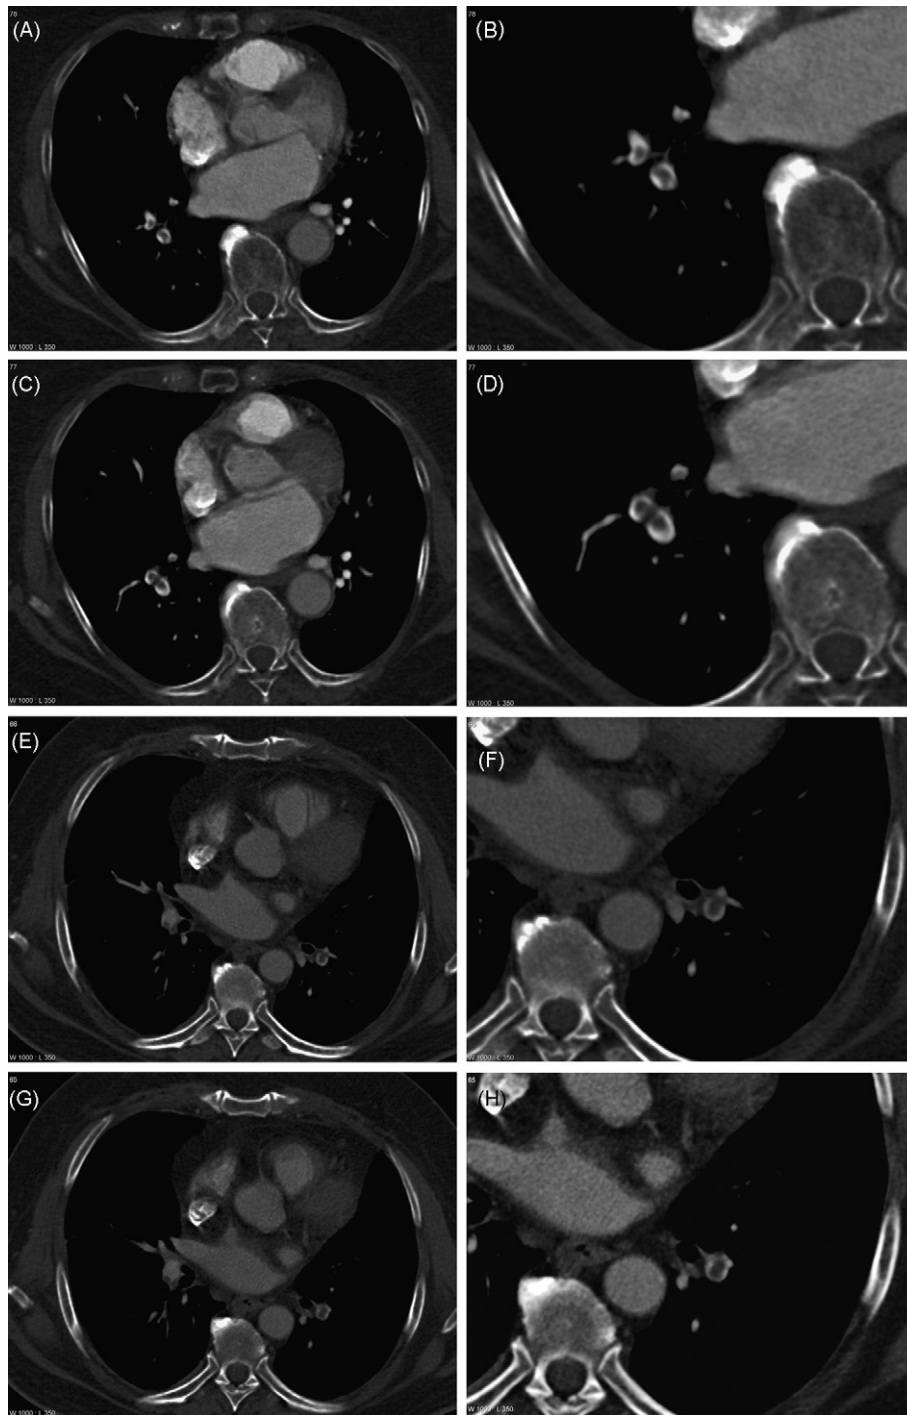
Comparison of iomeprol 400 (A–D) and iodixanol 320 (E–H) for visualization of pulmonary embolus at CTA (windowing: W 1000/L 350). Image sets of positive pulmonary embolus in two consecutive slices with pulmonary vessel contrast densities closest to the average density values obtained in this study are demonstrated. Images B, D, F and H are magnifications of images A, C, E and G, respectively to better demonstrate the greater contrast attenuation achieved with iomeprol 400 (B and D) compared with iodixanol 320 (F and H).
